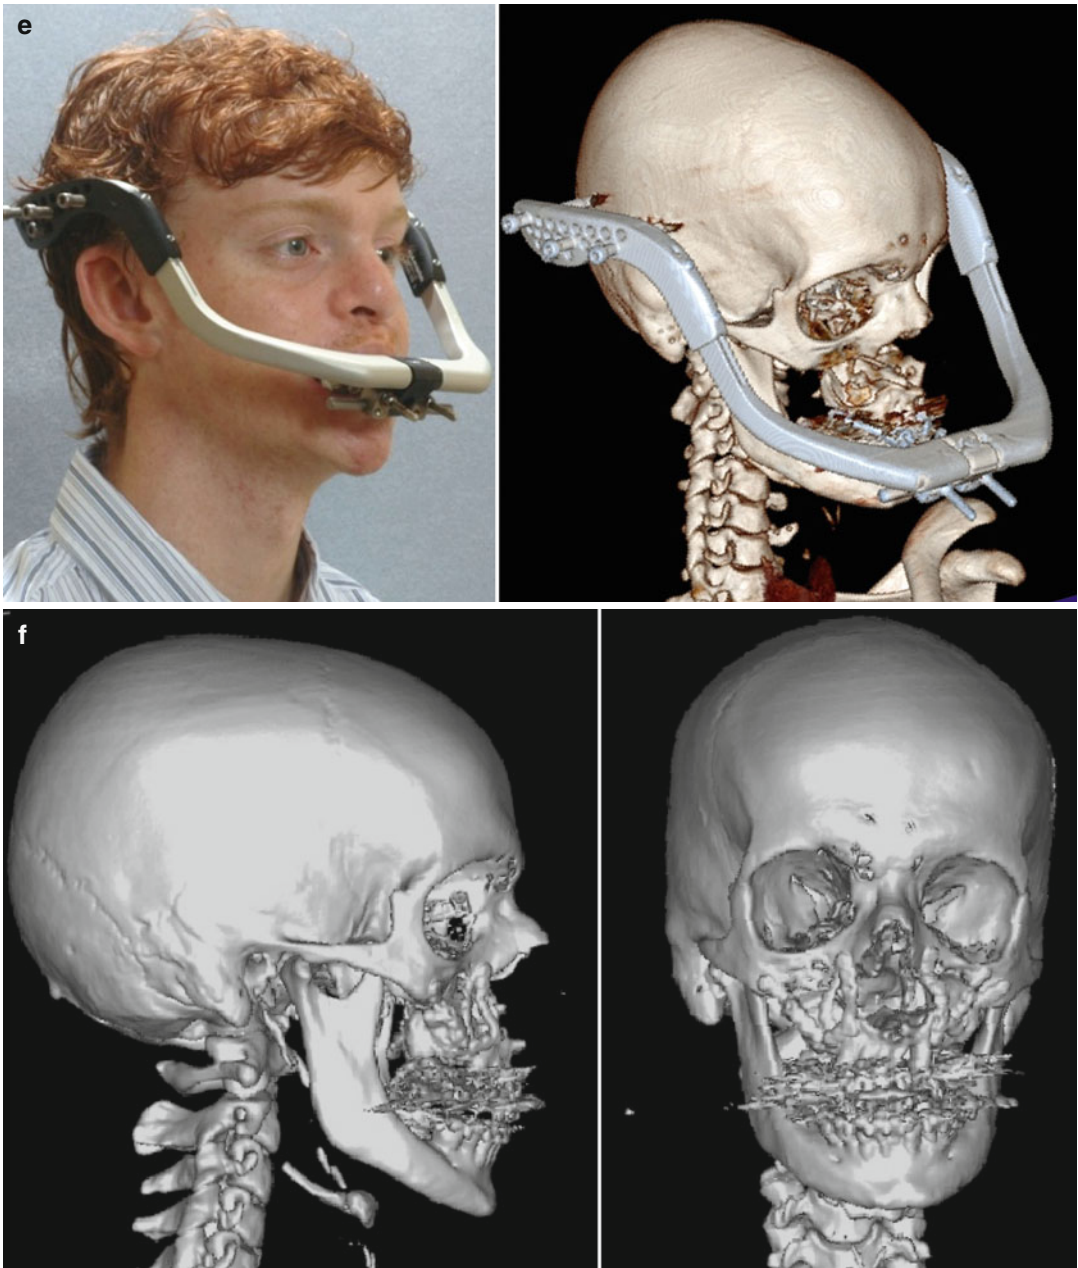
(continued) (e) 10 days after LeFort I osteotomy with distraction of maxilla into preferred position accomplished. (f) CT scan views after securing maxilla in new location with bone graft and plate and screw fixation
